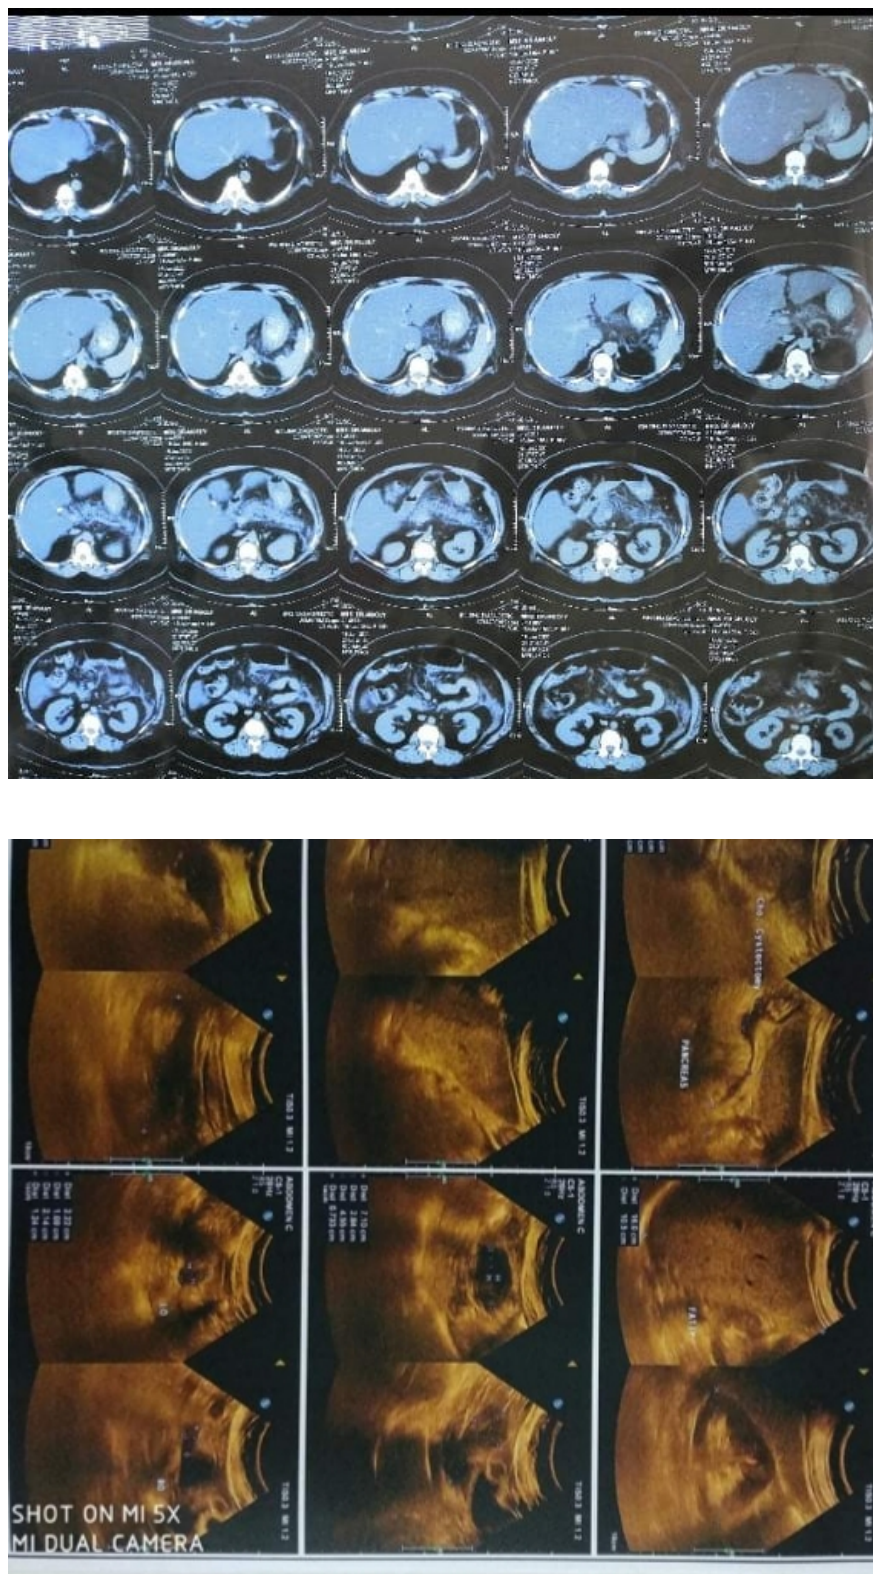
CT scan of Abdomen Figure-4 Ultrasonography of Abdomen
